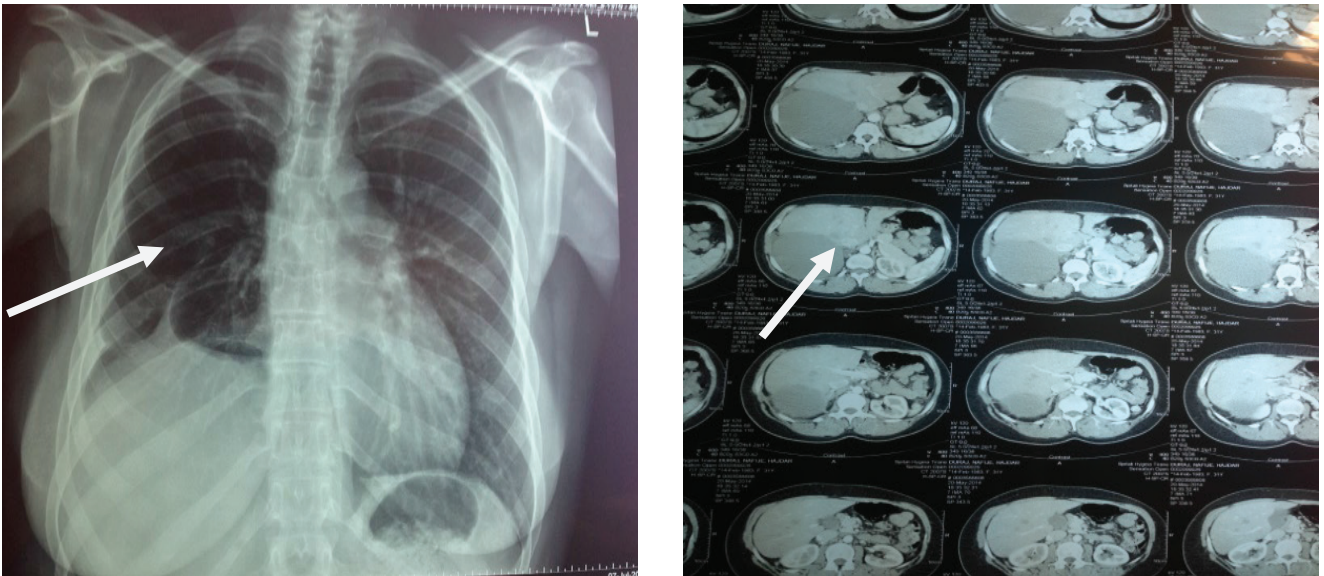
CT images (axial view) demonstrating the hourglass-shaped mass of fatty density (-110 UH), homogeneous, without contrast enhancement (arterial phase).
